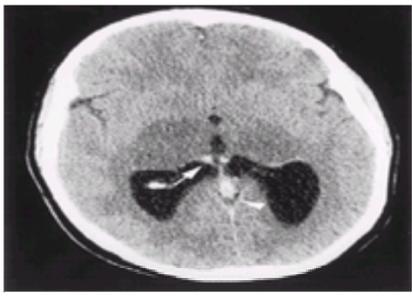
Venous sinus thrombosis with bilateral thalamic infarcts in a 24-year-old woman with 4 days of headache followed by several hours nausea and depressed consciousness. Nonenhanced computed tomography shows low attenuation changes in both thalami, with increased attenuation in the internal cerebral veins (*arrow*) and straight sinus (*arrowhead*).
